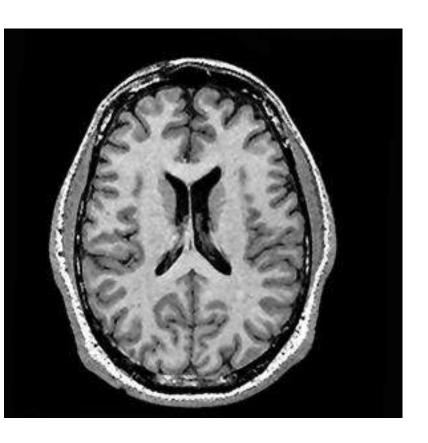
Patient M.E., normal T₁w images on MRI
